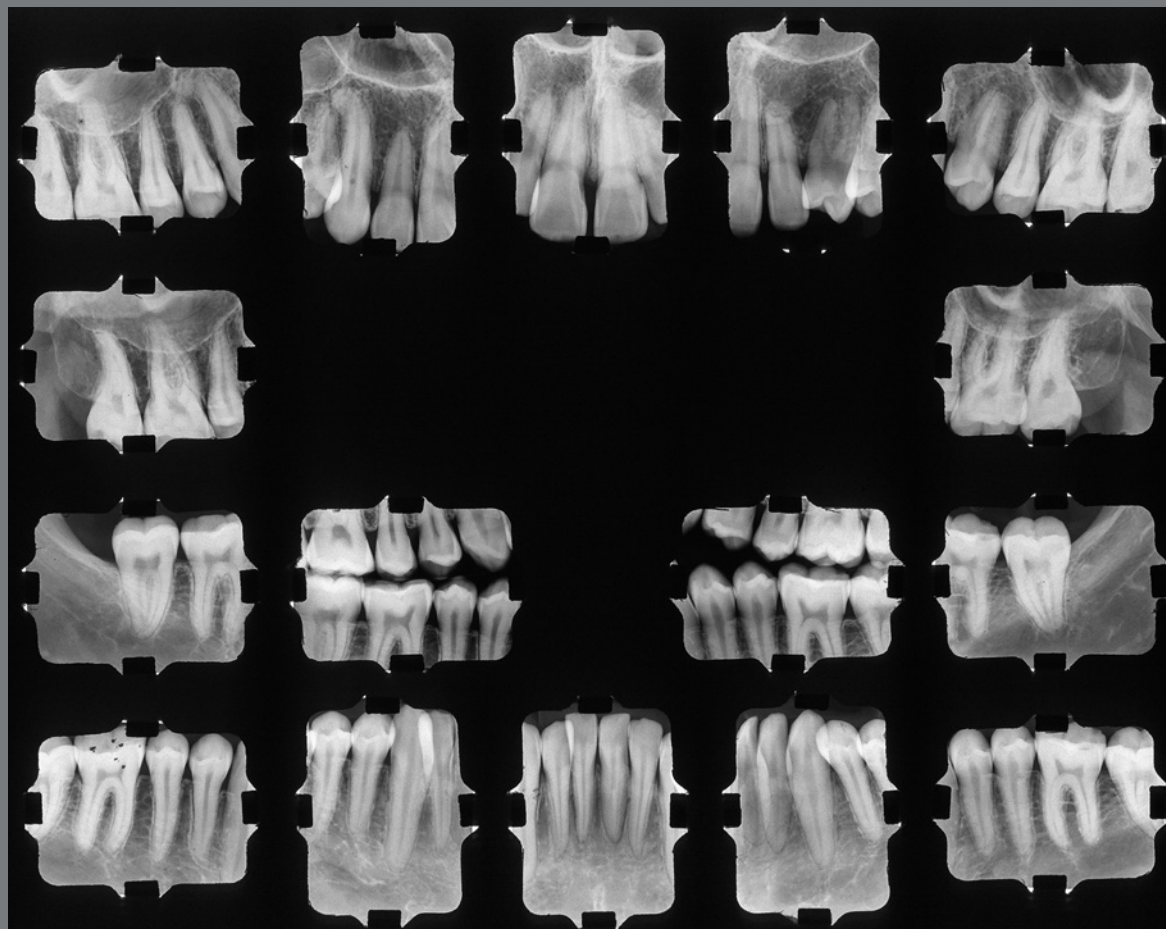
Initial periapical radiographs.
